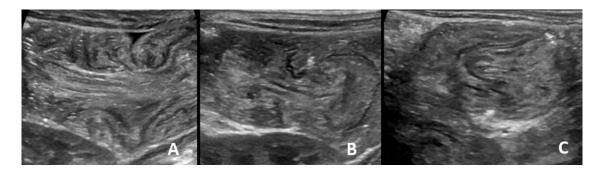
Ultrasounds of the left upper quadrant of the abdomen longitudinal to the axis of the bowel indicating intussusception. (A) Before first surgery. (B) Before second surgery. (C) One week after second surgery when patient was clinically asymptomatic.
